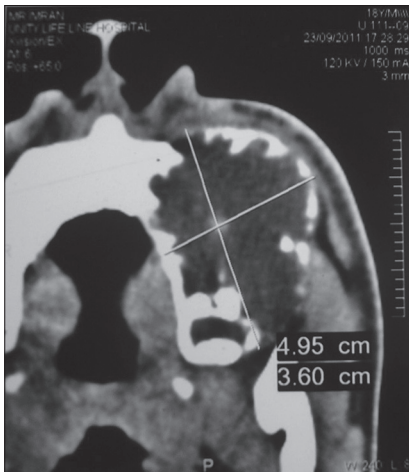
Computed tomography scan showing the extent of the lesion
